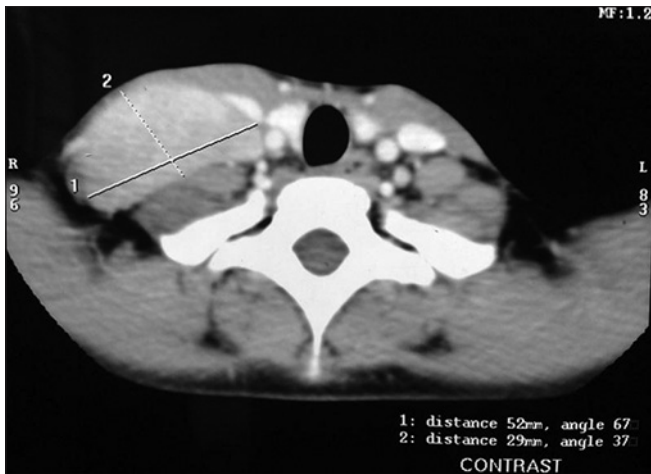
Computed tomography scan picture of the primary tumor
